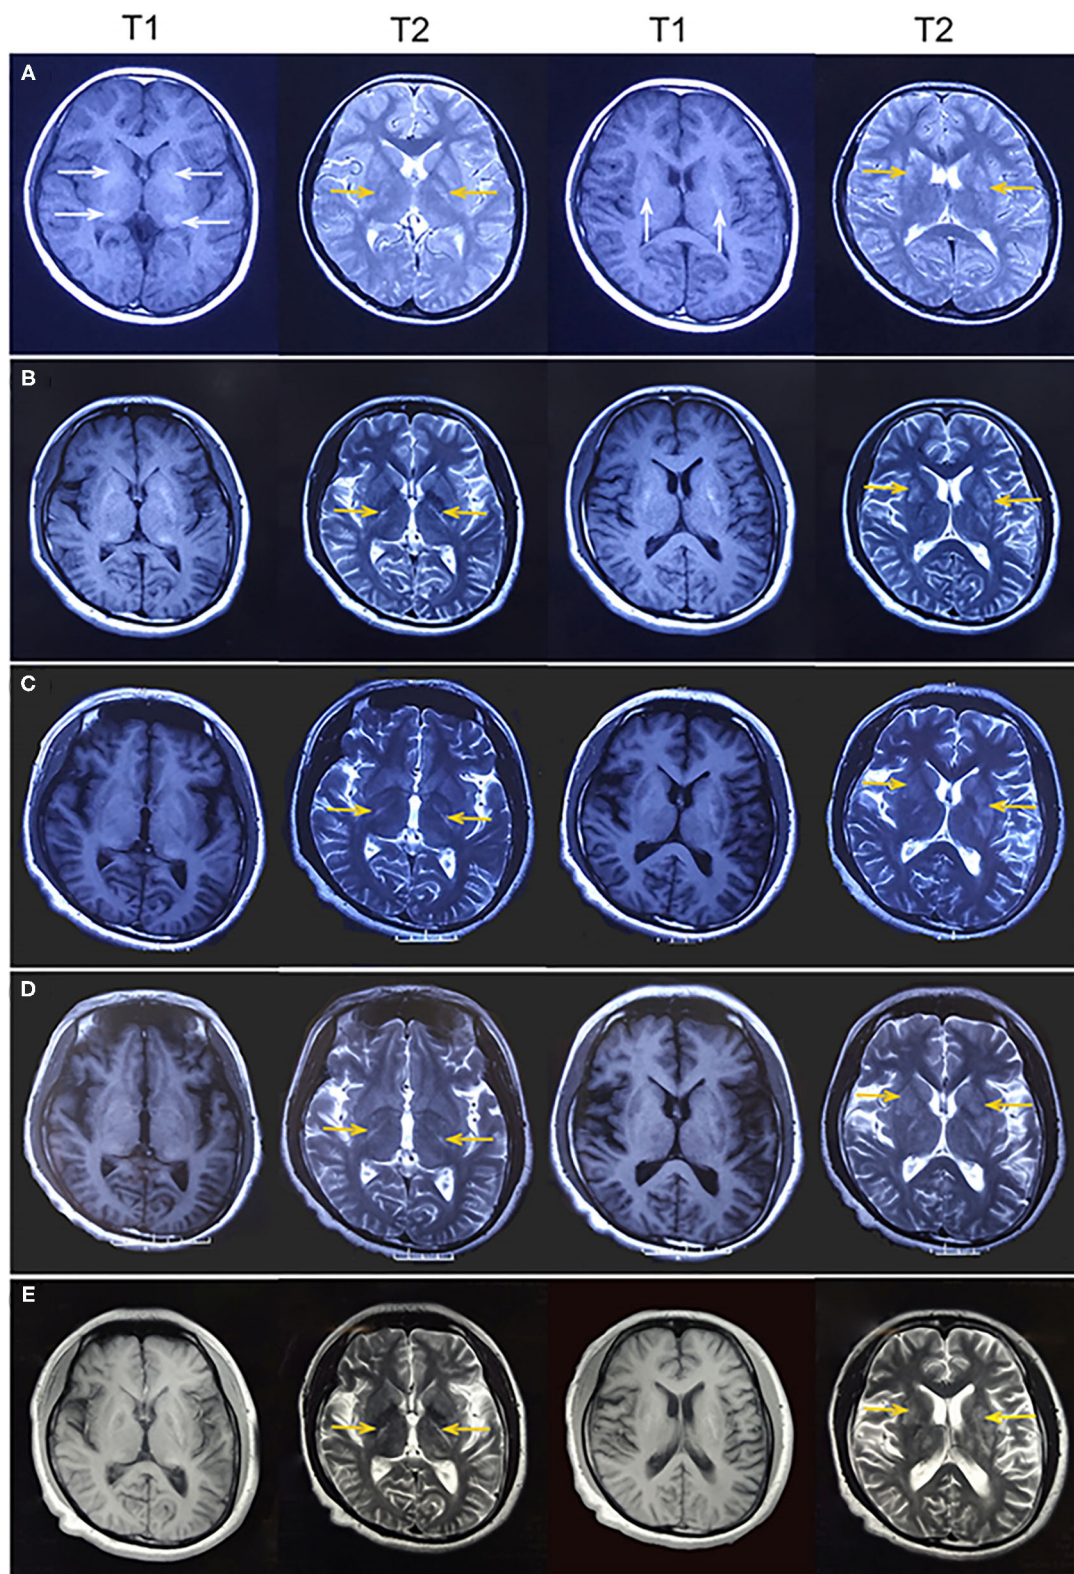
(A) At age 12 years, magnetic resonance imaging (MRI) revealed hyperintense on T1-weighted images and hypointense or hyperintense on T2-weighted images in the bilateral basal ganglia and thalamus (white arrowhead), which were coincident with areas showing calcifications on computed tomography. Some lesions were slightly hypointense or isointense on T1-weighted images, with T2 hyperintense in the bilateral internal capsule and periventricular areas (yellow
